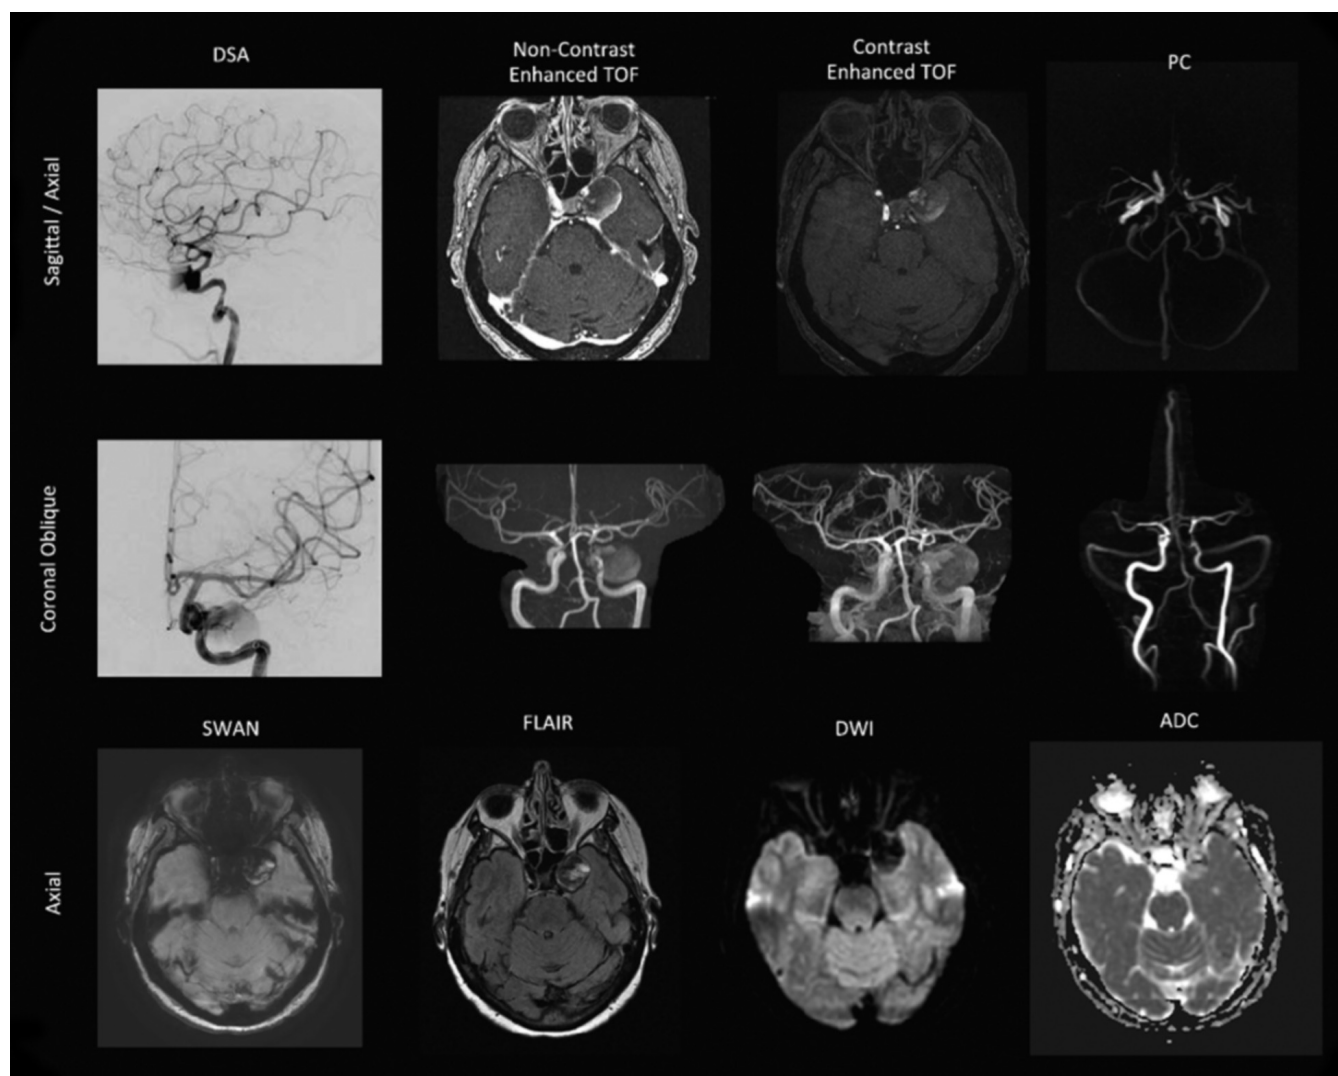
Postoperative imaging. DSA shows minor filling of the fundus as the contrast agent passes. This was supported by the MRI with noncontrast-enhanced and contrast-enhanced time-of-flight (TOF) and phase-contrast (PC) imaging. The aneurysm still appears large on TOF due to the short T1 of the thrombus. The phase-contrast images show near-zero velocity in the aneurysm. Susceptibility-weighted angiography (SWAN), T2-weighted fluid attenuated inversion recovery (FLAIR) imaging, diffusion-weighted imaging (DWI), and a calculated apparent diffusion coefficient (ADC) map transecting the aneurysm are also shown.
